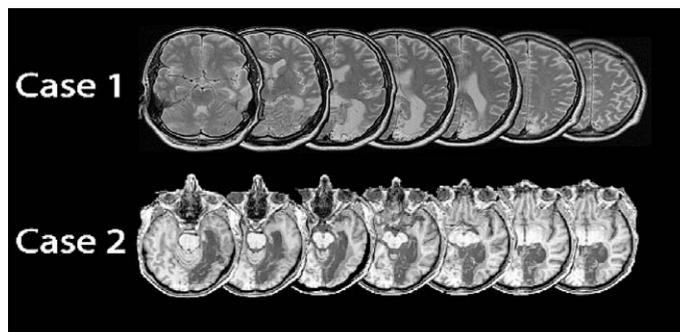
Axial MRI or CT images of the lesions of the hemianopic cases.
